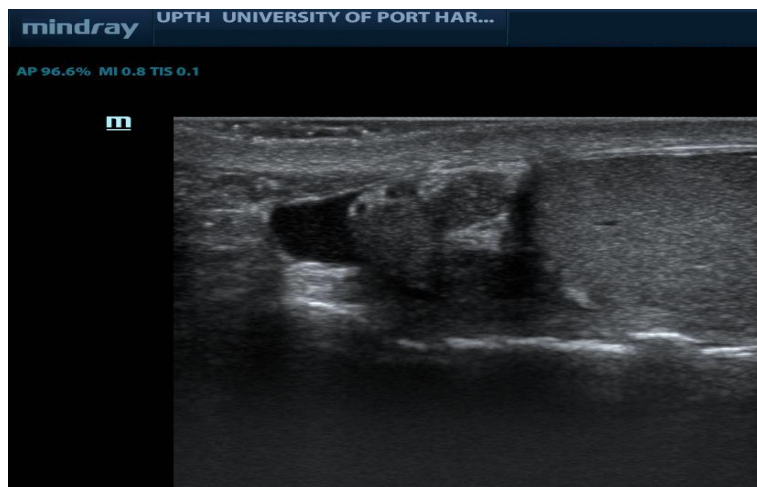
Epididymal enlargement. Sonogram shows an enlarged epididymal head with reduced echogenicity
